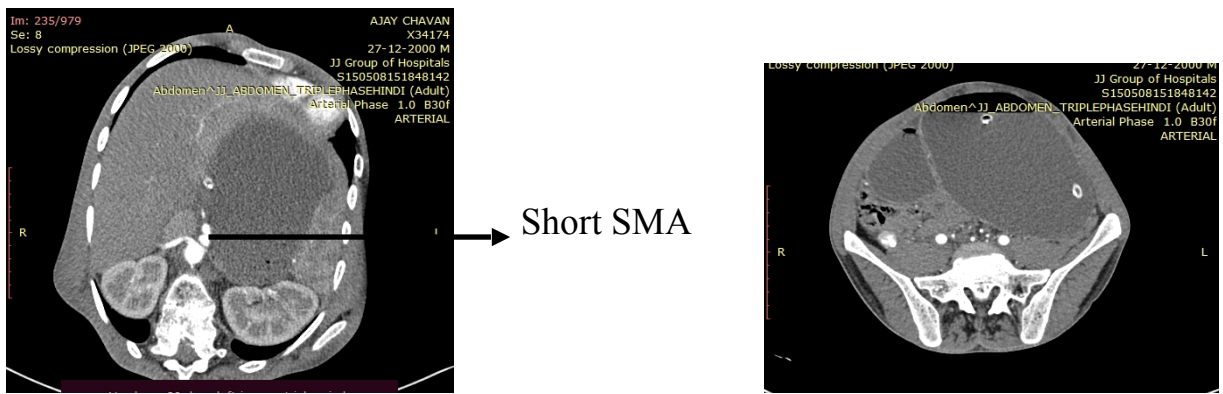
CT scan of the abdomen indicating superior mesenteric artery
